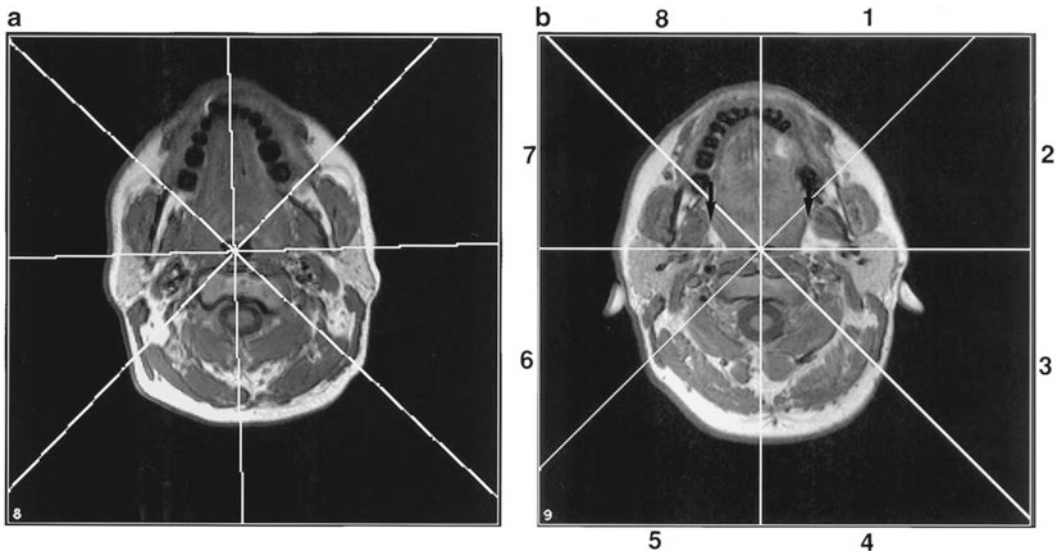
Cross-sectional T1-weighted magnetic resonance scans of a control subject (a) and a non-obese patient with sleep apnea (b), showing distribution of neck fat. The anterolateral fat deposits (segments 2 and 7) are marked with *arrows*. (Reproduced from Mortimore et al. (1998). With permission from the American Thoracic Society)
